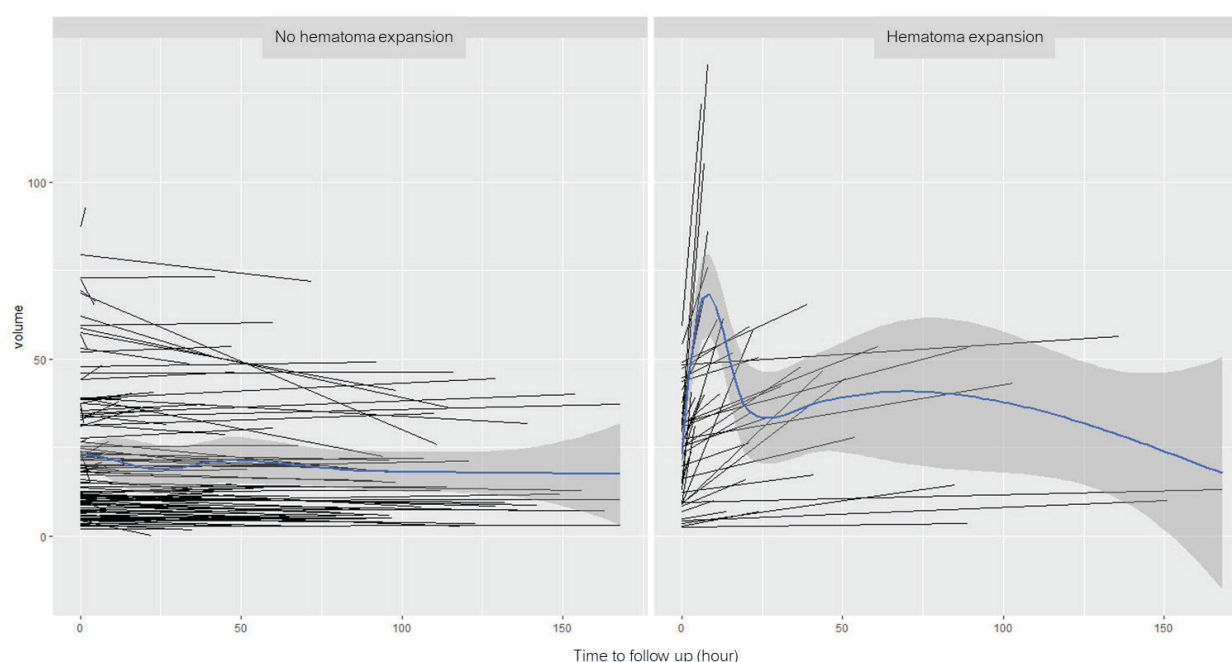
The association between the expansion volume and the time to follow-up CT scan
